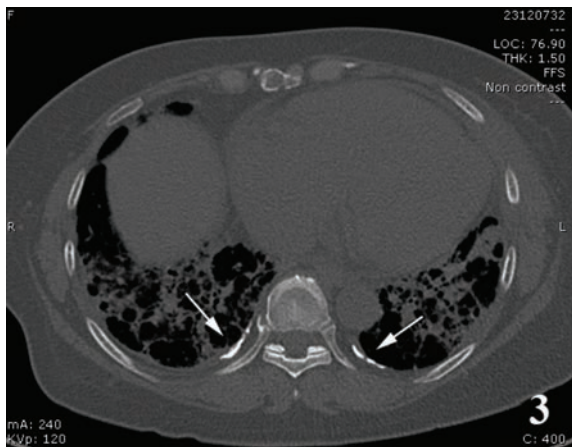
The axial CT scan of the chest (bone window) shows calcified pleural plaques at bilateral costovertebral junction (arrows).
